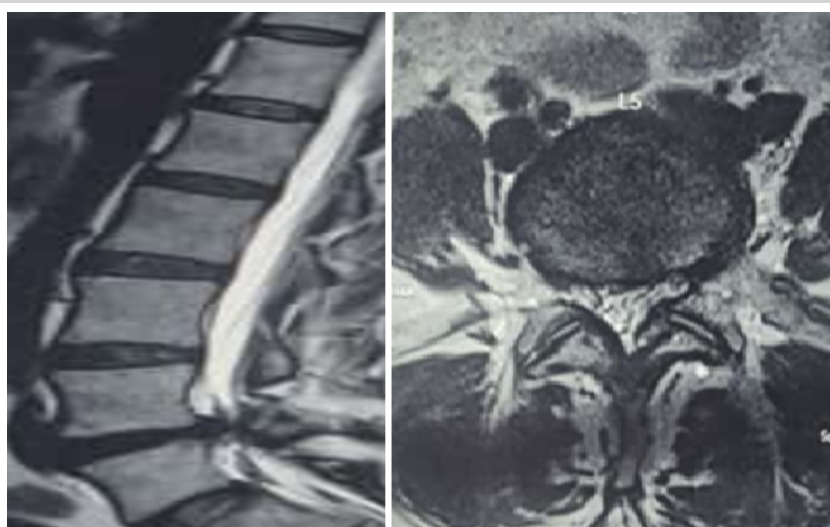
Magnetic resonance imaging shows right lateral recess stenosis with left L4-L5 foraminal disk prolapse in sagittal and axial cuts.
